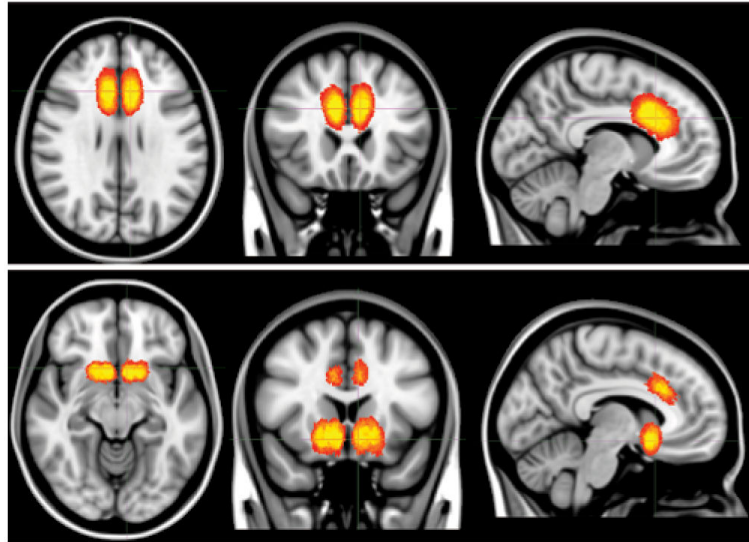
Representative postoperative MR images of anterior cingulotomy and limbic leucotomy. Upper: Anterior cingulotomy. T1-weighted, magnetization-prepared rapid acquisition gradient echo axial, coronal, and sagittal images (*left to right*). Lower: Limbic leucotomy. T1-weighted axial, spoiled gradient–recalled acquisition coronal, and T1-weighted sagittal images (*left to right*).
